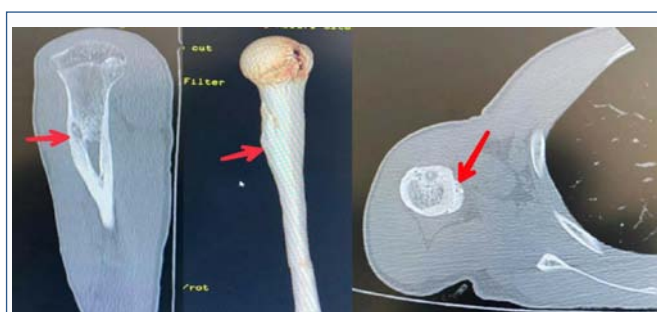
Showing CT imaging revealed a well-defined cortical nidus.
